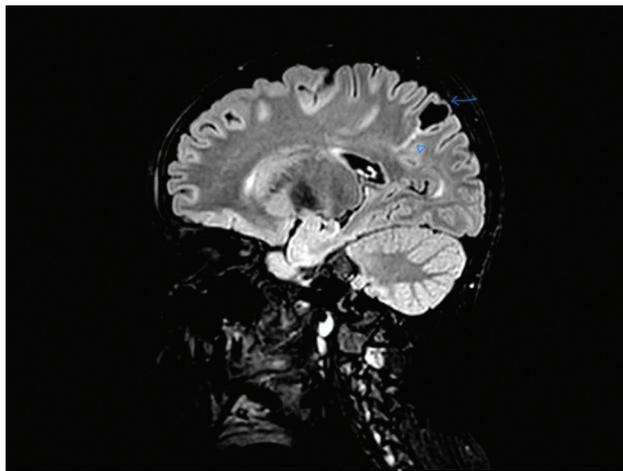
Sagittal section of the brain with FLAIR-sequence demonstrating a FLAIR-suppressed oval cystic lesion (lobulated) in the *left parietal* region (*arrow*), with a hyper-intense signal (*arrowhead*) extending from its inferior boundary toward the lateral ventricle, consistent with the “transmantle sign” of FCD. FCD, focal cortical dysplasia; FLAIR, fluid-attenuated inversion recovery.
